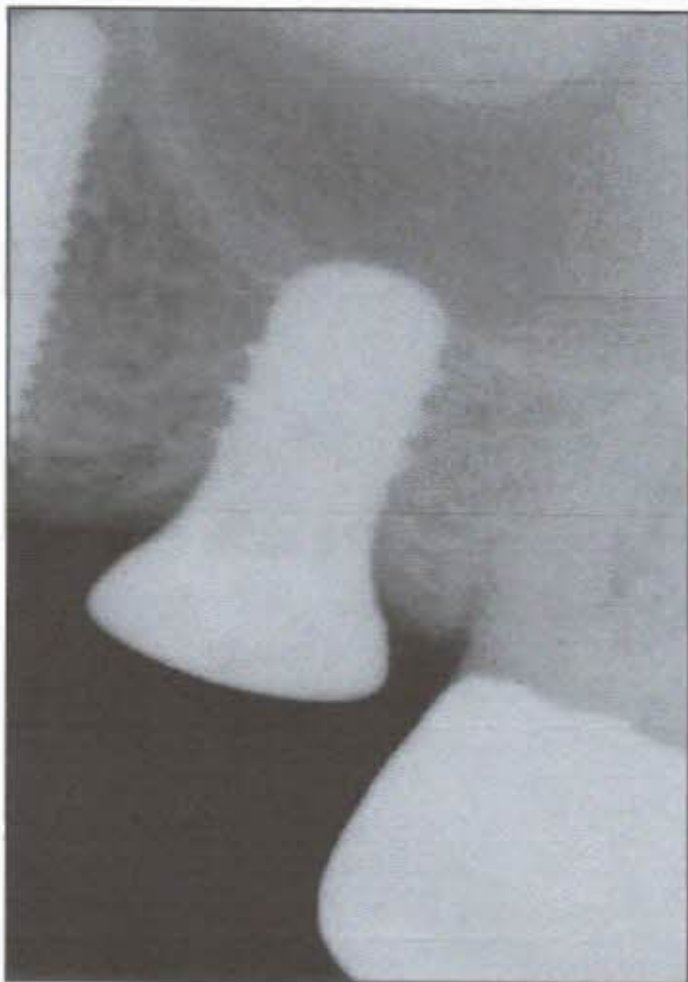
4 month post operative radiograph.
